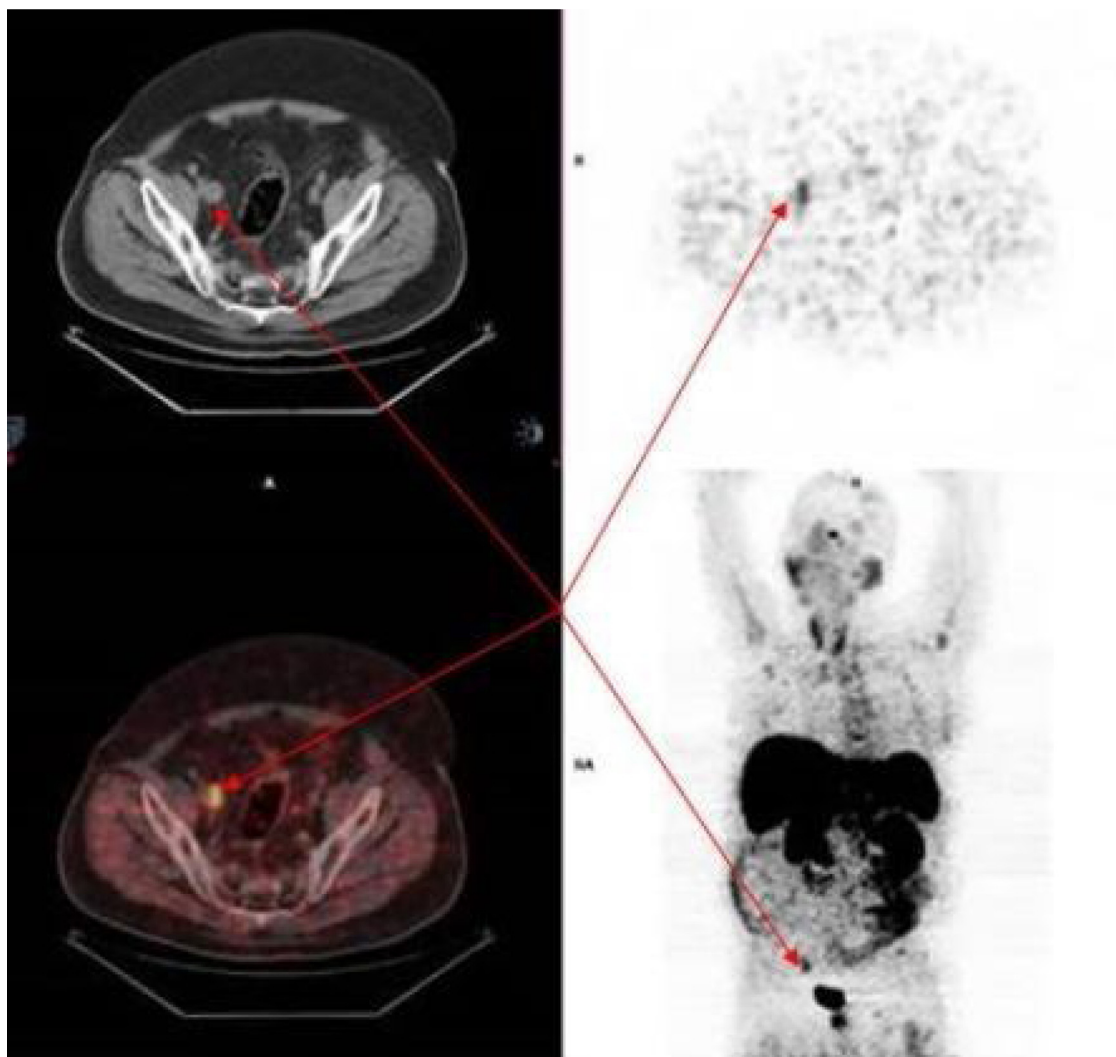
^{68}Ga -DOTATATE PET/CT. Red arrows highlight the external iliac nodal metastasis at the CT stand-alone view (left upper panel), PET only imaging (right upper panel) and eventually fused PET/CT image (left bottom panel) and maximum intensity projection (right bottom panel). (For interpretation of the references to color in text, the reader is referred to the web version of the article).
